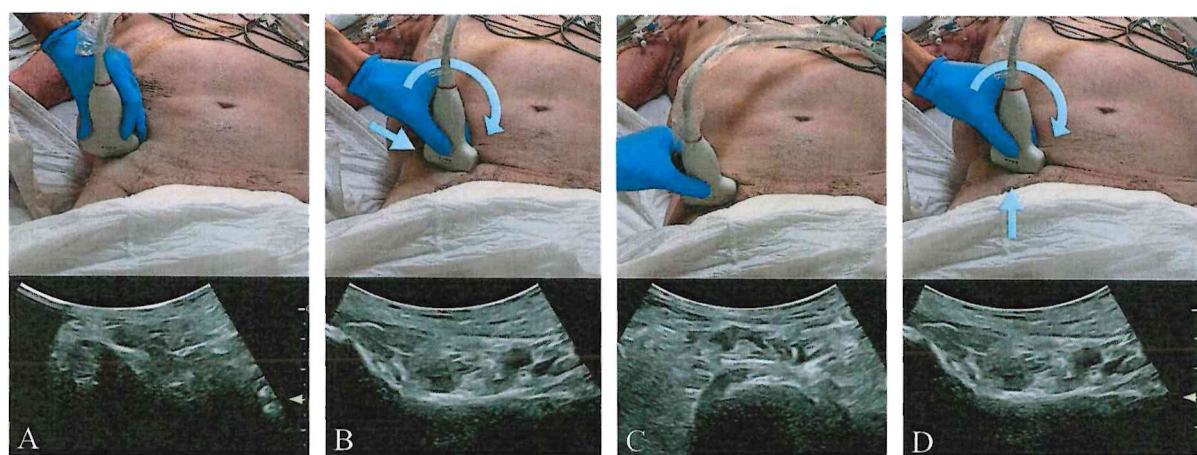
Scanning technique 1: A, B) a curvilinear low-frequency ultrasound probe (2-5 MHz) is initially placed in a transverse plane over the AIIS (A), then is moved infero-medially and is aligned with the pubic ramus by rotating the probe approximately 30-45 degrees (B). Scanning technique 2: C, D) a curvilinear low-frequency ultrasound probe (2-5 MHz) is initially placed in a transverse plane over the hip joint (C), is moved cranially until the IPE and AIIS are visualized and then rotated approximately 30-45 degrees (D).
